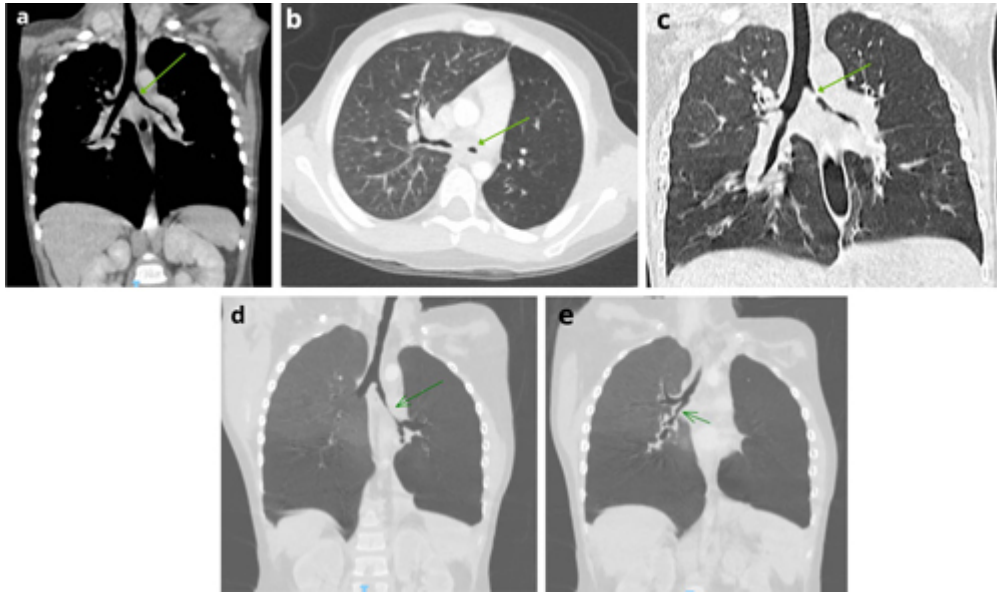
HRCT. (a–d) Significant reduction in the diameter of the right main bronchus, with narrowing of up to 90% along its entire length, most notably in the distal segment (arrow). (e) Diffuse thickening of the walls of the intermediate bronchus (arrow), with a decrease in calibre of approximately 70% in the most distal portion. There is complete atelectasis of the left lower lobe. The right lower lobe is expanded, presumed related to partial obstruction of the intermediate bronchus leading to air trapping, although a distal airway granulomatous component cannot be excluded. ↩
